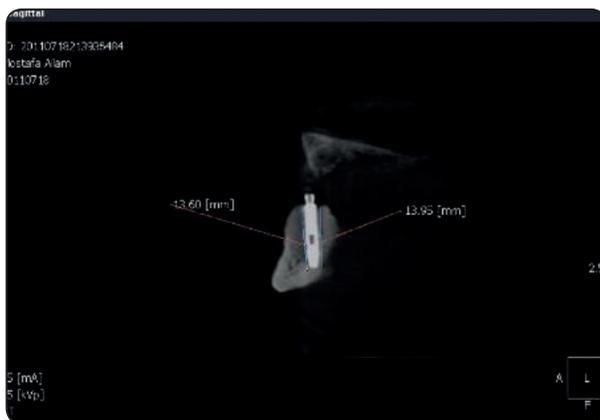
peri-implant bone height measurements using CBCT
